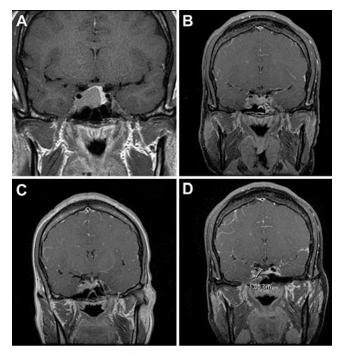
Coronal post-Gd T1-weighted MR images obtained in a 31-year-old woman with a GH-secreting pituitary adenoma. She underwent partial tumor resection due to cavernous sinus involvement. A: Preoperative. B: Three months postoperative. C: Six months after starting SSA. D: One year post-SSA treatment.
